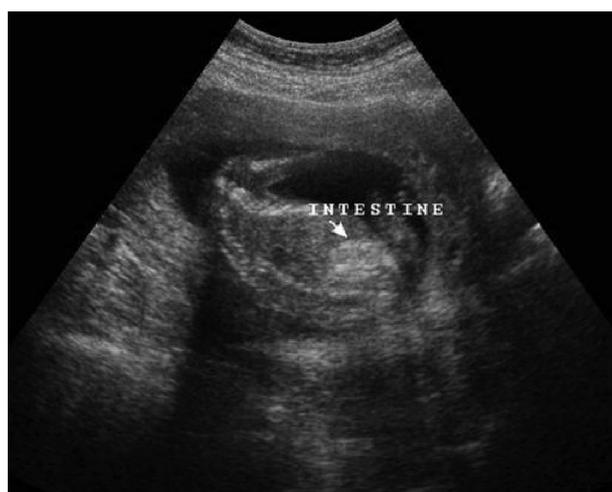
Transabdominal sonogram reveals echogenic bowel of fetus (arrow).
